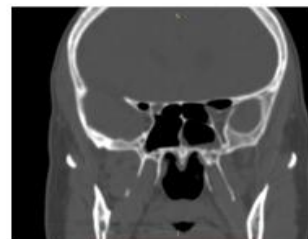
Coronal CT showing type IV optic nerve bilaterally (arrow)-The nerve course lies immediately adjacent to the sphenoid and posterior ethmoid sinus. Blue circle: Onodi cell;
